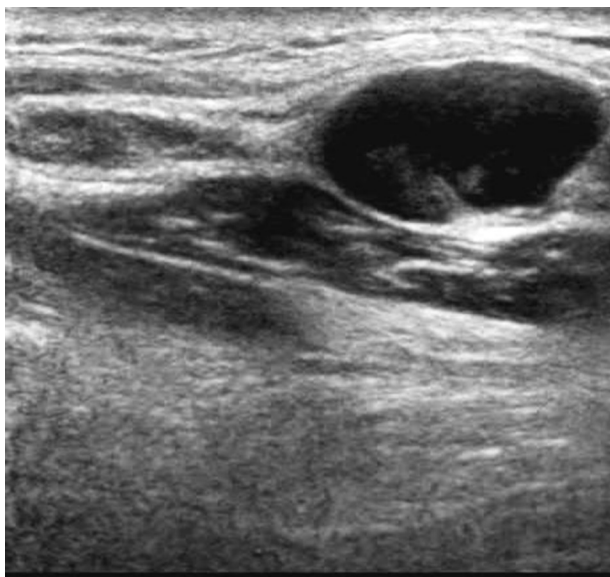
Longitudinal view of ultrasound of the back of the neck.
